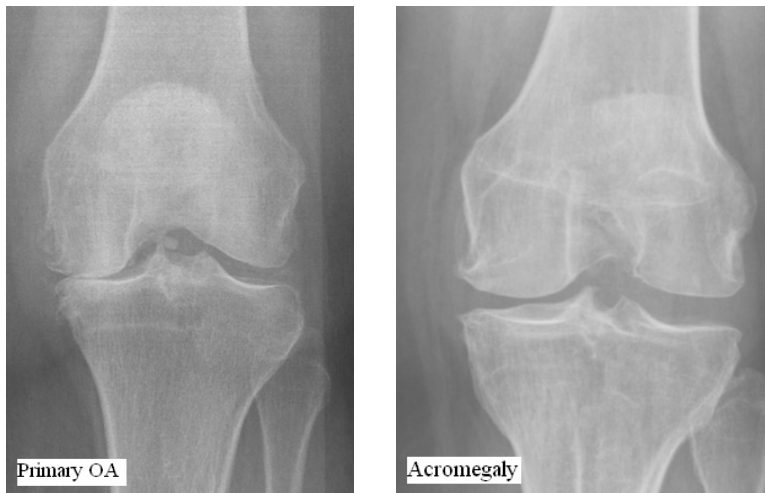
Radiographic features of osteoarthritis in the knee joint in a characteristic patient with primary OA (left) and acromegaly (right)
